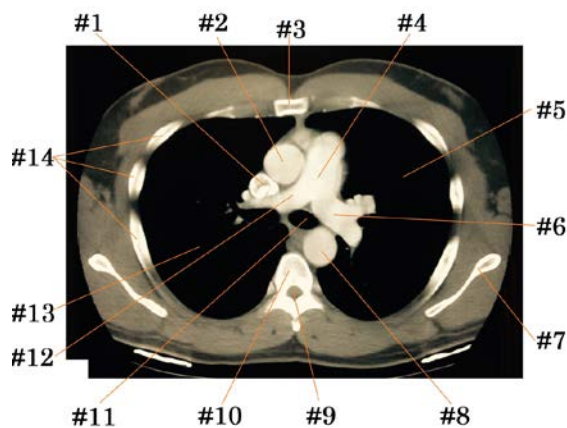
CT axial cross-sectional image of the thoracic region.
